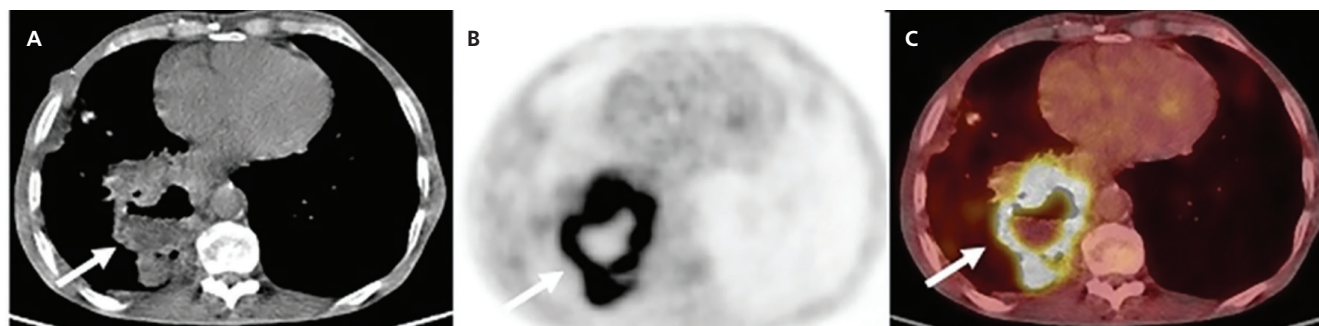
Squamous cell carcinoma. Axial CT (A), ^{18}F -FDG PET (B), and fusion PET/CT (C) images show high ^{18}F -FDG uptake (SUV_{max} : 15.30) on a cavitary mass measuring approximately 93 mm with thick, irregular walls and an internal air-fluid level (arrows)
